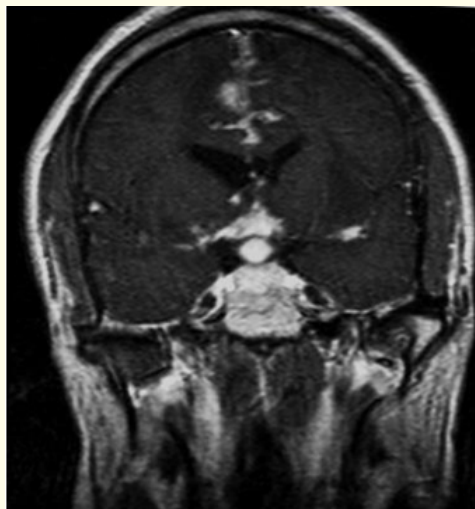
Showing MRI image showing supra-sellar enhancement suggestive of sarcoidosis.
